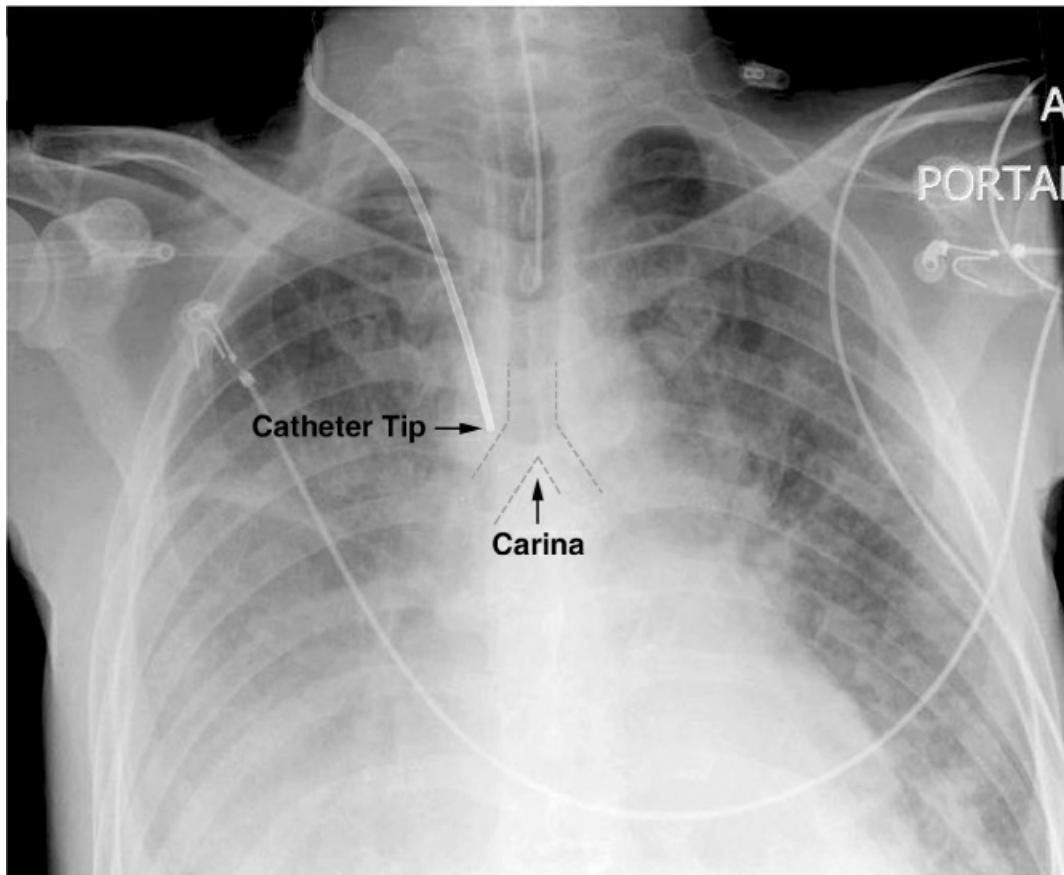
Portable chest x-ray showing the proper placement of a central venous catheter. Note that the tip of the catheter is at the level of the carina (i.e., the tracheal bifurcation, highlighted by the dotted lines), which lies just above the junction between the superior vena cava and right atrium. Image digitally enhanced
